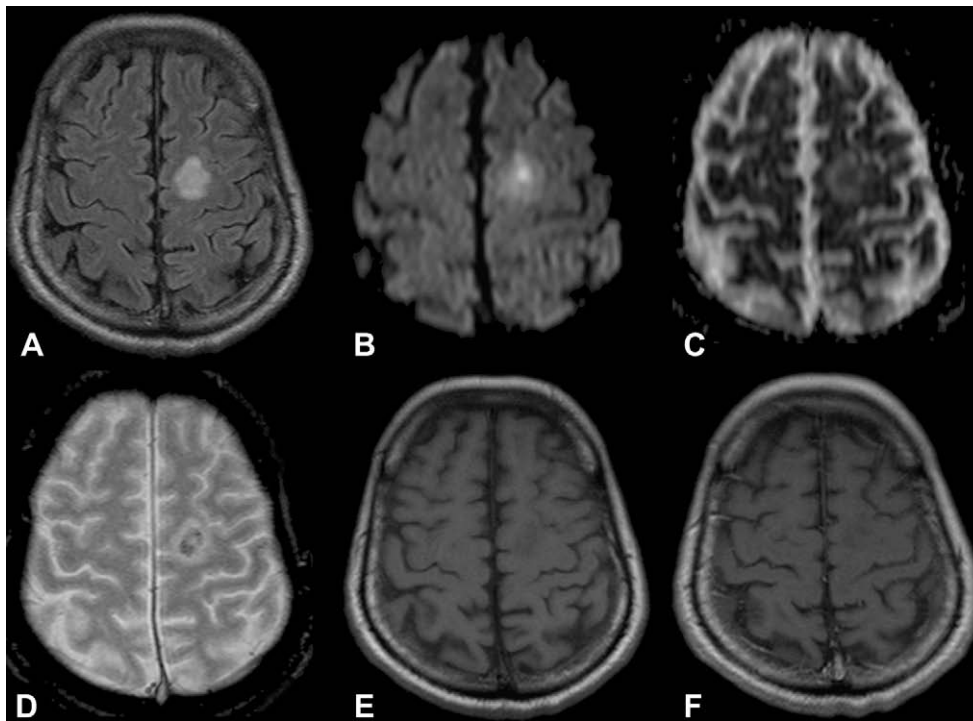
MRI of the brain. MRI of the brain performed on day 15 demonstrates areas of high signal intensity on FLAIR (A) and T2-weighted images (not shown) within the brain. The center of the lesions is hyperintense on diffusion-weighted imaging (B) and hypointense on apparent diffusion coefficient (ADC) map (C) indicating restricted diffusion. Some vasogenic edema may be observed. Gradient echo T2*-weighted images (D) display areas of low signal intensity, indicating the presence of calcification, iron, or micro-hemorrhagic components. The lesion is isointense with the cortical gray matter on T1-weighted sequences (E) and no enhancement is observed after gadolinium-injection (F). No leptomeningeal enhancement is present.
